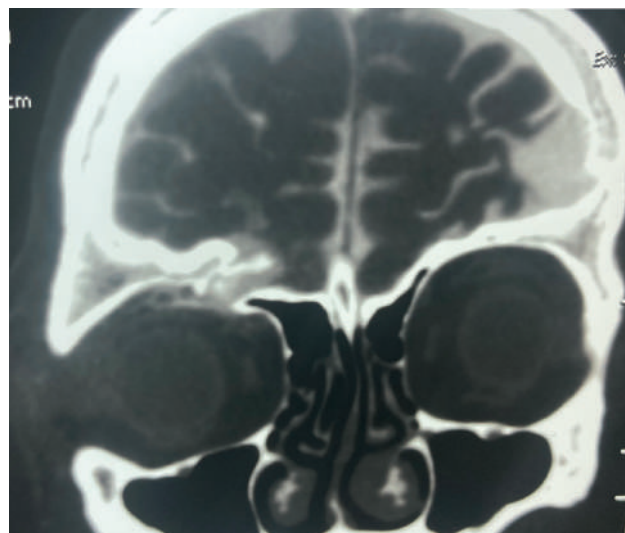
T2-weighted magnetic resonance imaging scan of the brain in coronal view showing the craniopalpebral fistula.
